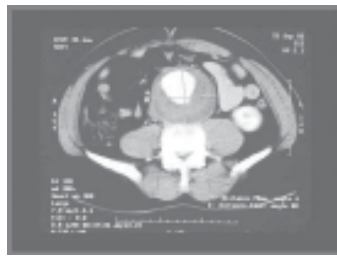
CT scan showing an aneurysm in the infra-renal segment of the aorta with layered thrombus
